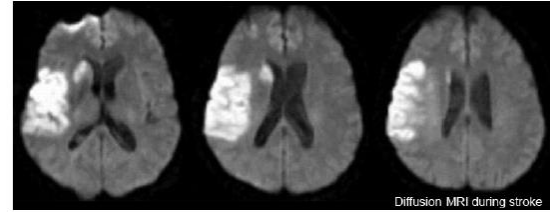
Diffusion MRI Brain Image during a stroke: The bright areas on the left side of the brain indicates restricted diffusion due a stroke[2].
